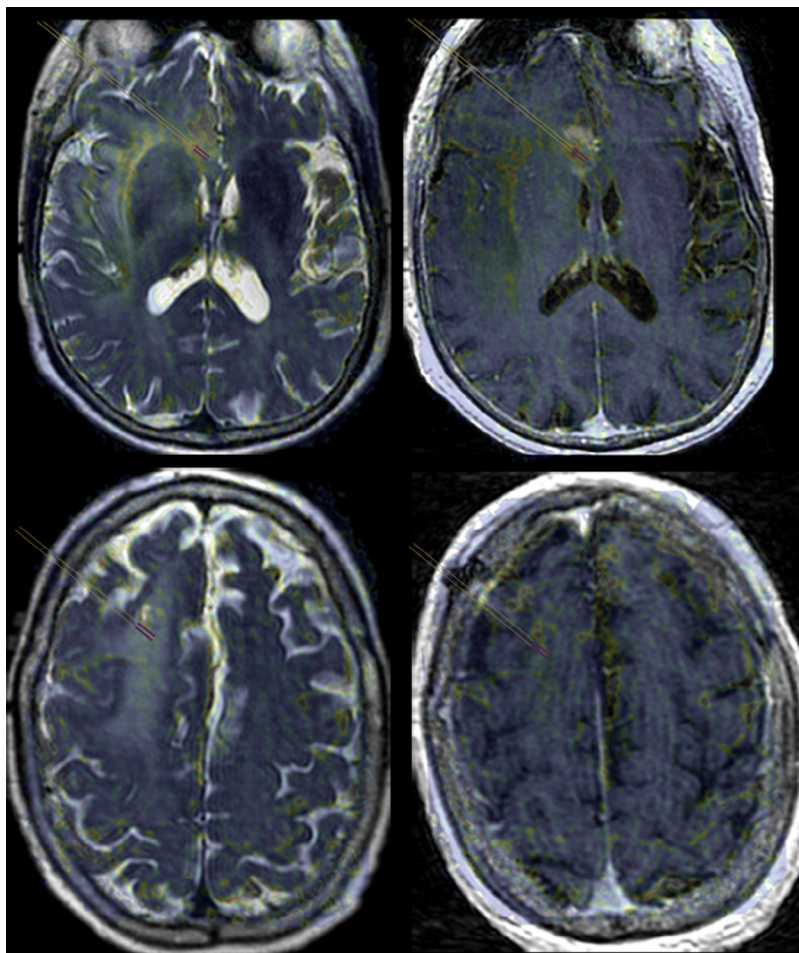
Fusion of T1 ρ and morphologic magnetic resonance imaging allows for spin-lock contrast quantification. Fusion of the region of interest (purple bars) placed on a T1 ρ spin-lock contrast map that has been fused to T2 (left) and T1 postcontrast (right) images allows for quantification of T1 ρ metrics within the nonenhancing tissue sampling sites from diagnostic (top) and nondiagnostic (bottom) regions.
